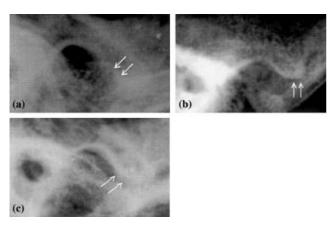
Radiograph of the mandibular fossa having respective morphological alternation. (a) Erosion of inferior of fossa (arrows). (b) Flattening of articular eminence (arrows). (c) Sclerosis of inferior of fossa (arrows)
